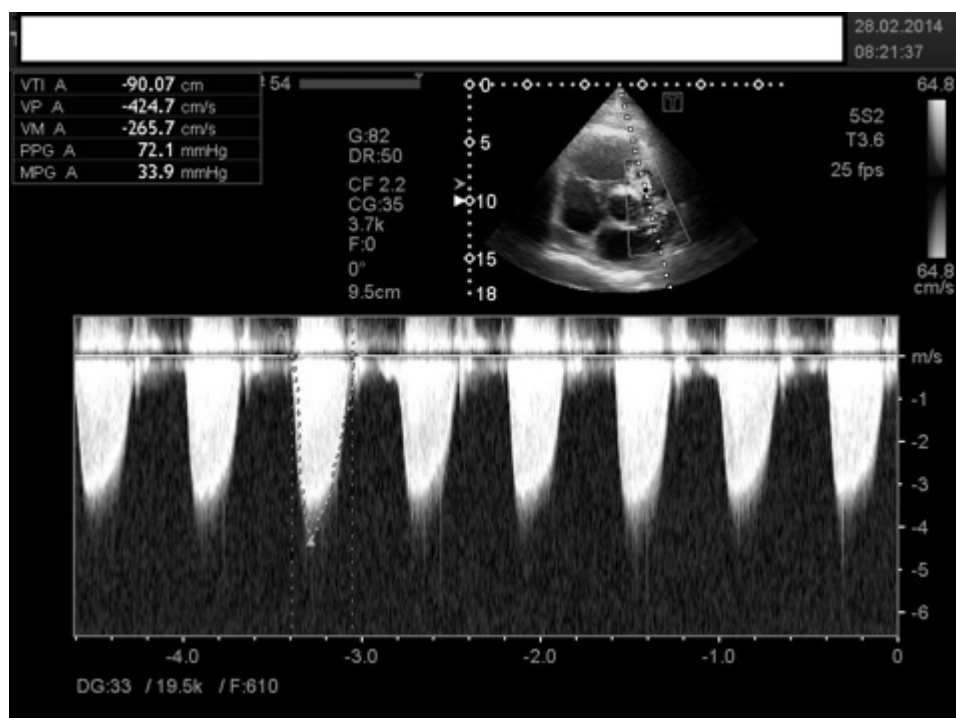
Echocardiography: a pressure gradient in the narrowing of pulmonary artery
